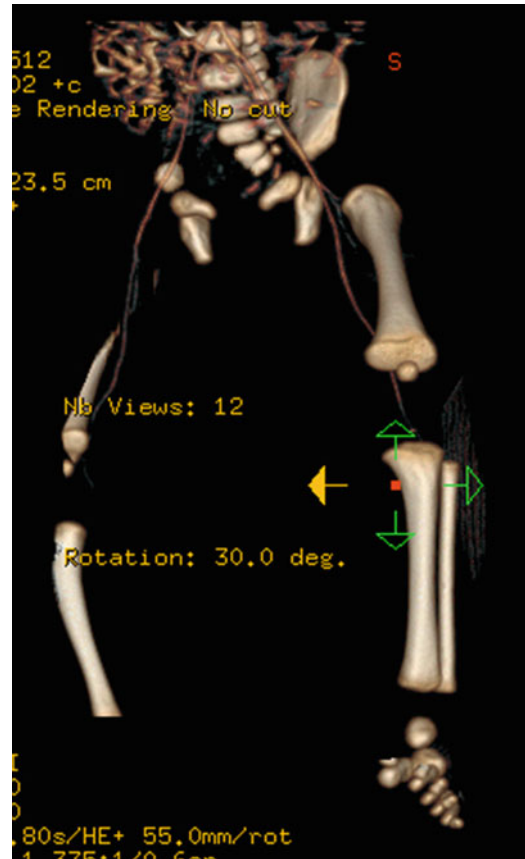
This female newborn was delivered at 34 weeks of gestation via cesarean section complicated by polyhydramnios. Amniocentesis showed 46, XX. The face was asymmetric during crying. Echocardiogram showed a subaortic perimembranous ventricular septal defect (VSD). The baby was noted to have shorter right leg, absent right foot, absent thumb, and clinodactyly with a longer 4th finger. Skeletal survey showed a hypoplastic right first rib, partial fusion of the right radius and ulna, a shorter right radius, and also the absent right thumb with a corresponding absence of the first metacarpal bone. Frontal skeletal radiograph showed a congenital anomaly of the right lower extremity with unilateral fibula and foot agenesis. Soft tissue atrophy/hypoplasia of the leg is also seen. The figure here showed frontal 3D volume rendering reconstruction of both lower extremities demonstrating absence of the right fibula and foot. A computerized tomography angiogram of the lower extremities revealed normal popliteal arteries on both sides with an absent peroneal artery on the right side (not shown). She received prosthesis for the right lower extremity subsequently. The combination of absent depressor anguli oris along with the VSD prompted consideration of the possibility of Cayler cardiofacial syndrome in this patient (Courtesy of Dr. Hassan Ibrahim)
